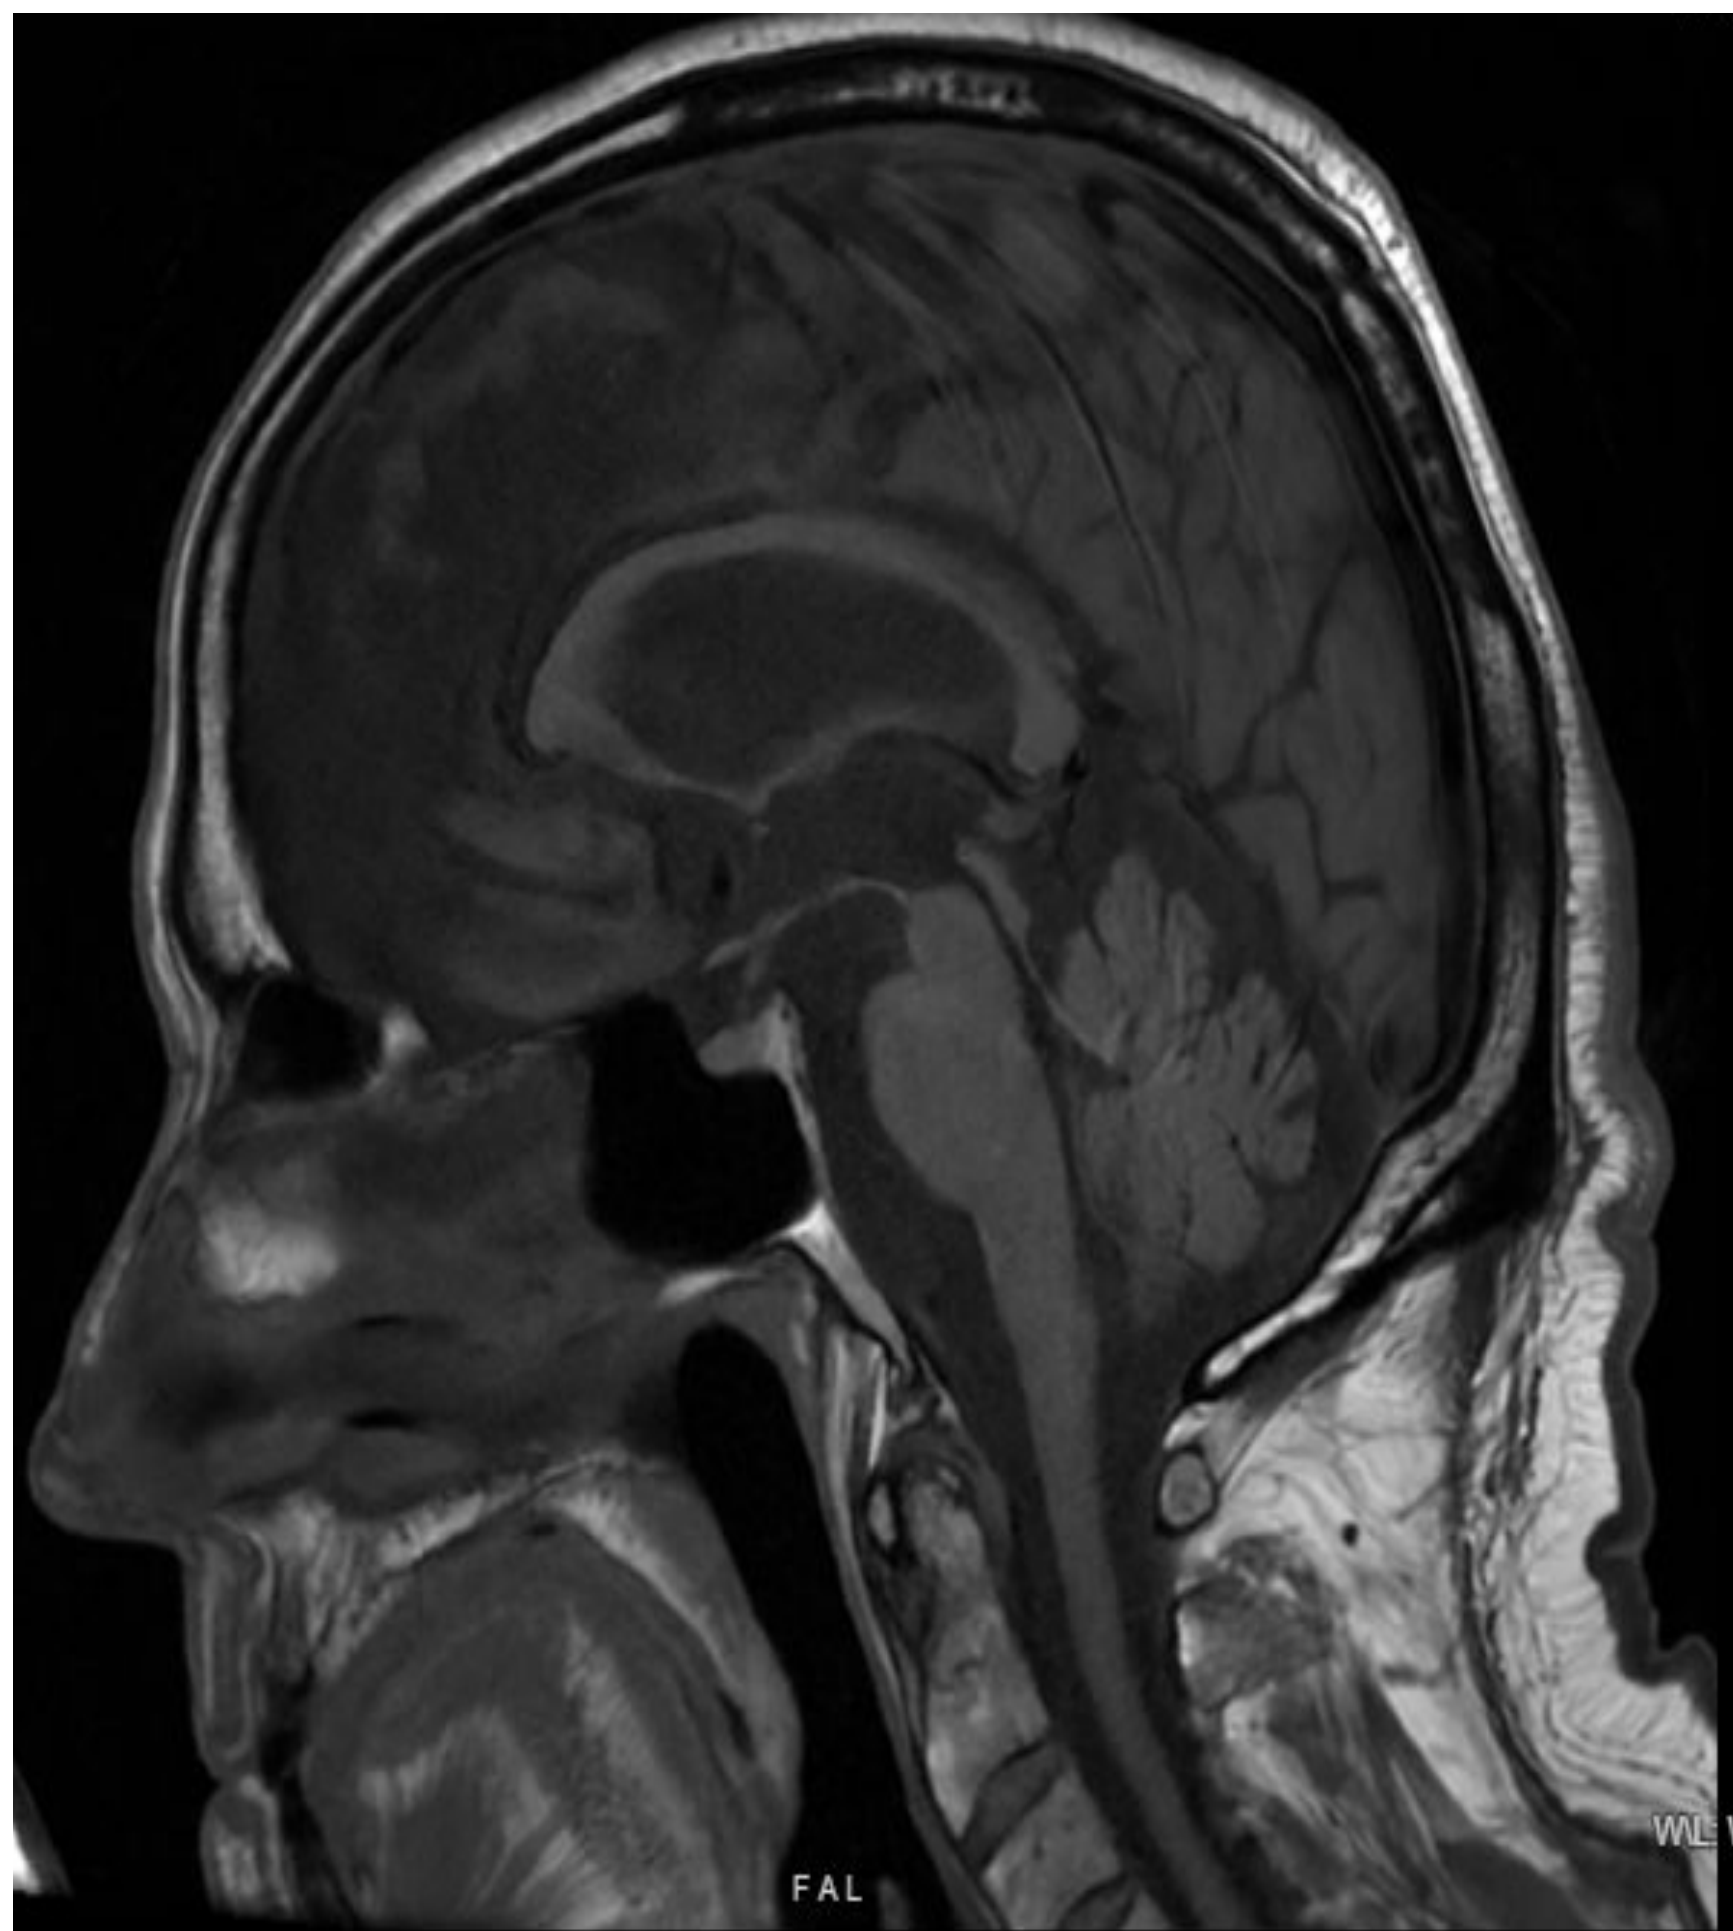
Sagittal MRI Brain with Hummingbird Sign
